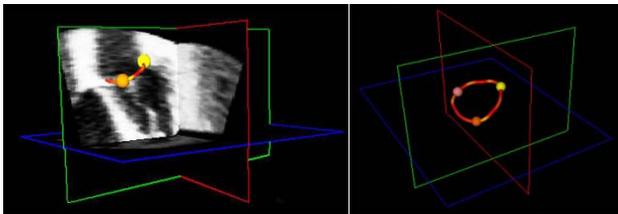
Three-dimensional visualization of the tricuspid annulus, superimposed on the 3D echocardiographic data (left) and with plane outline (right). Dots represent the commissures and spline colors represent local curvature.
